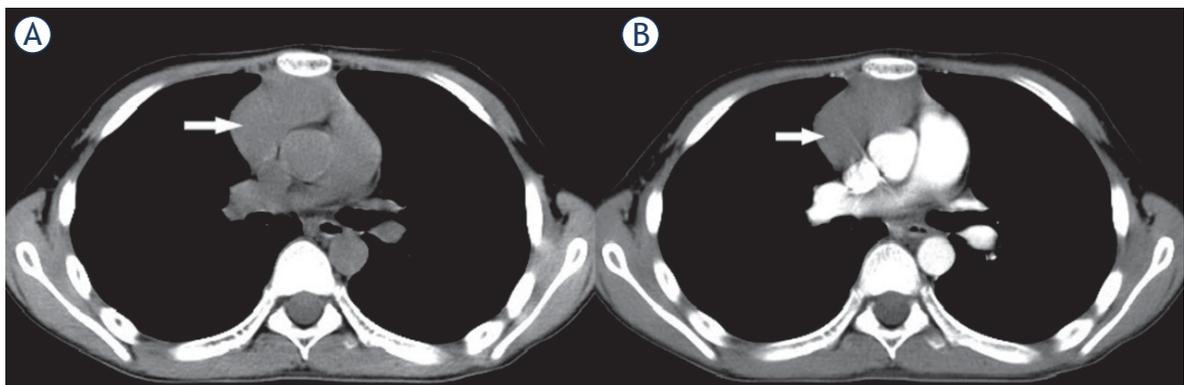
A 13-year-old boy with PTCL in the anterior mediastinum. (A) Axial non-contrast CT image shows an oval, well-defined mass with homogeneous density in the anterior mediastinum (white arrow). (B) Contrast-enhanced CT image shows the tumor with homogeneously mild enhancement (white arrow). Tumor recurrence was not noted during the 36-month follow-up period.
